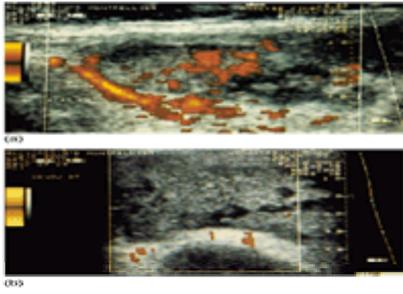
Juvenile chronic arthritis affecting the knee in a 5-year-old girl (by courtesy of Dr A. Couture, Montpellier, France). (a) Power Doppler shows hypervascularization of the active pannus. (b) After intra-articular injection of steroid, there is a decrease of power Doppler signal within the pannus.
